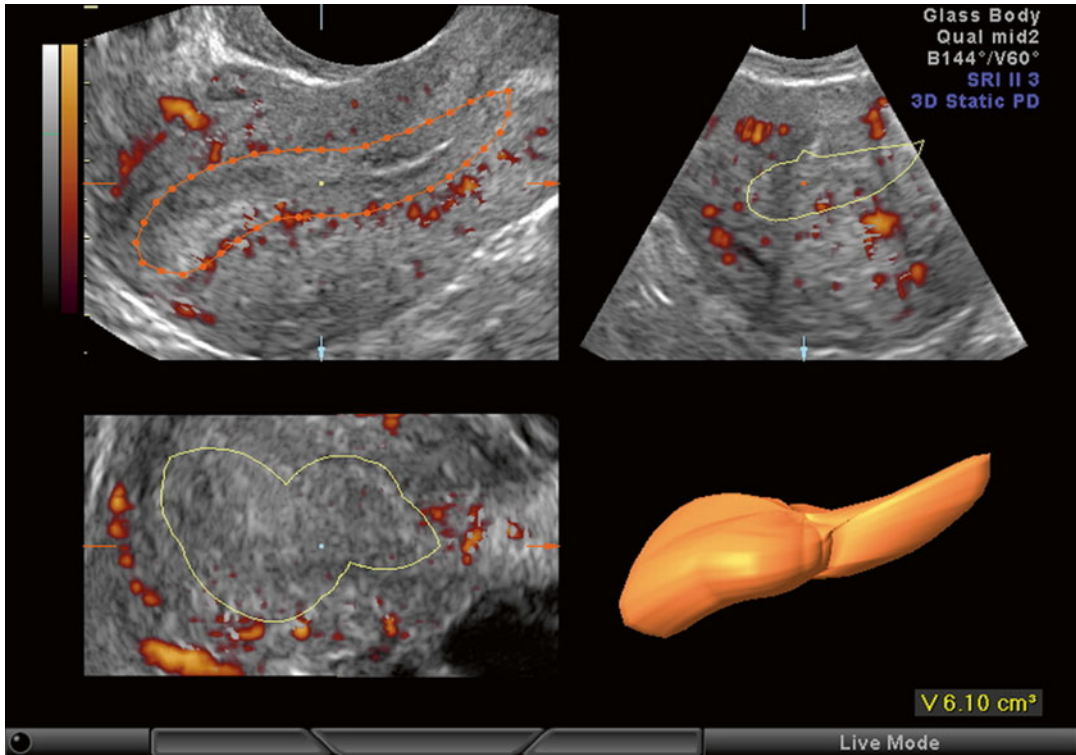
Endometrial vascularization using 3D power Doppler
